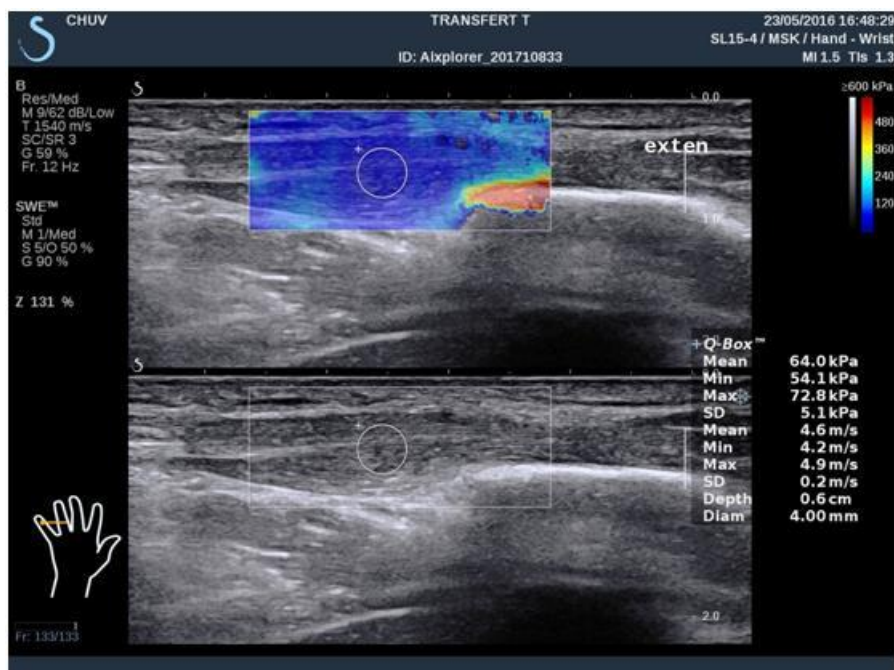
B-mode ultrasound (low) and elastographic (high) recording during the 2nd stage of the transfer (AE).
